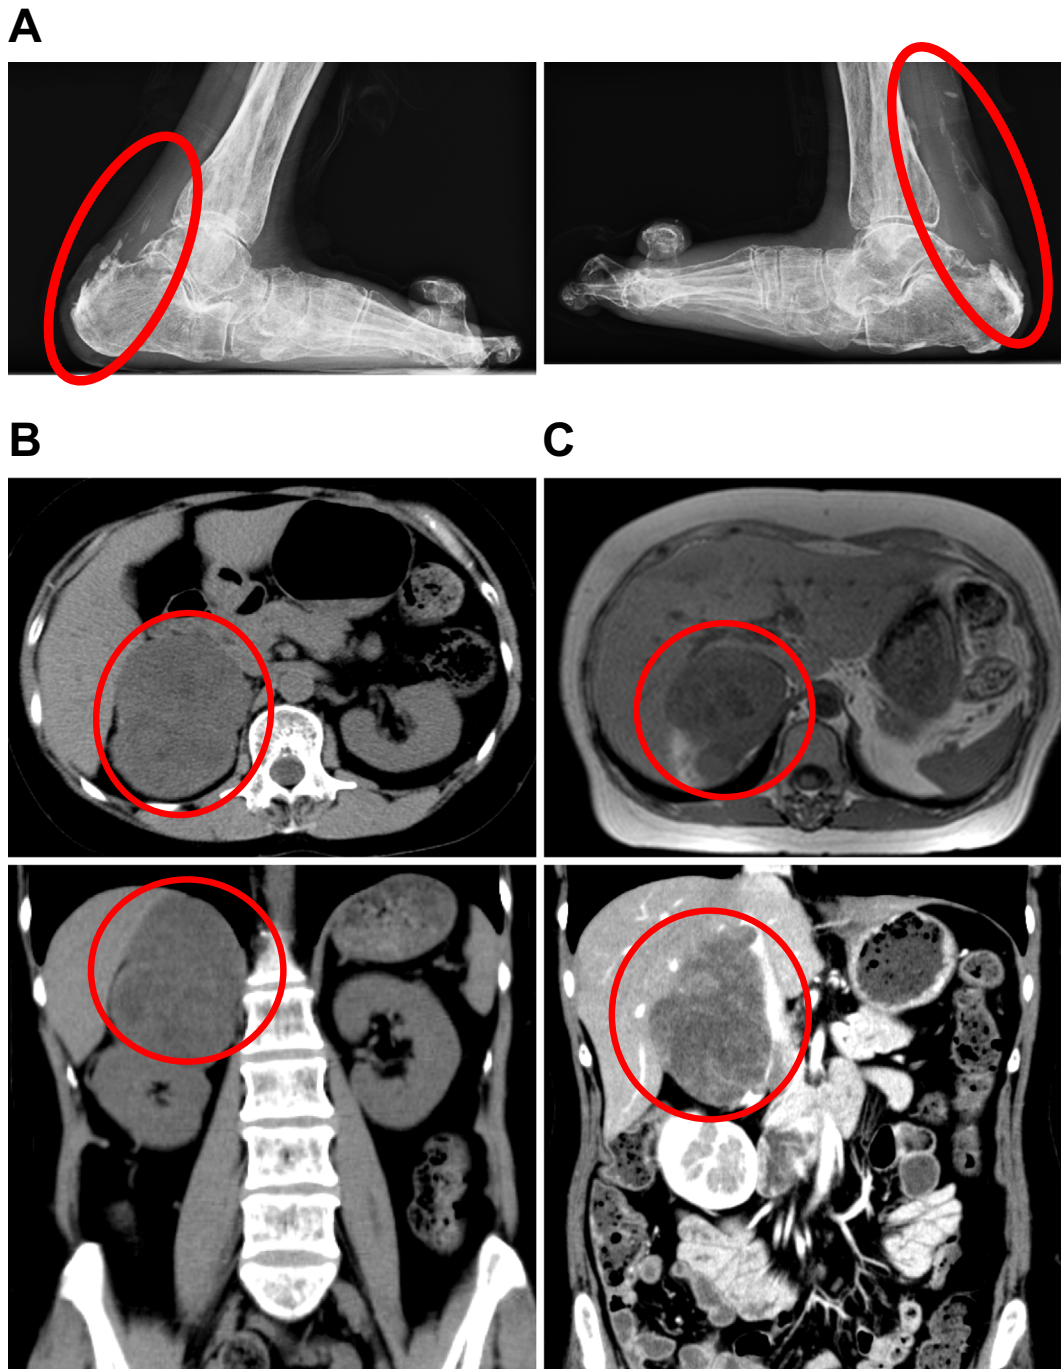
(A) Significant and segmented calcification in the Achilles tendon on X-ray. (B) Neoplastic lesion in the adrenal gland on CT. The maximum diameter was approximately 8 cm, and the inside showed a mosaic pattern, including a substantial ratio of low-density area. (C) Neoplastic lesion in the adrenal gland on MRI. The maximum diameter was approximately 8 cm, and it had a high-density area due to calcification.
